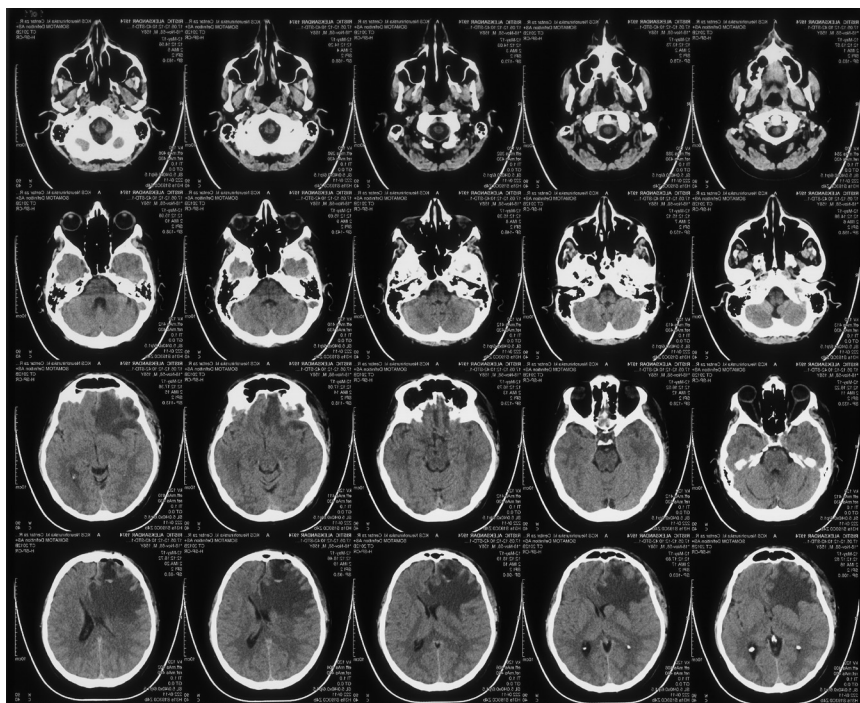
Postoperative brain CT images, axial view, showed no residual brain tumor.
